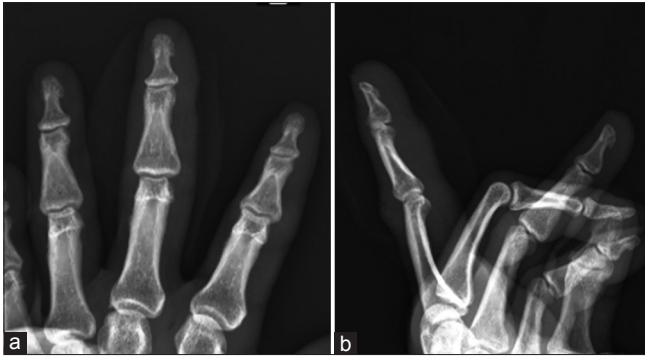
(a and b) Follow-up X-ray showing concentric reduction
